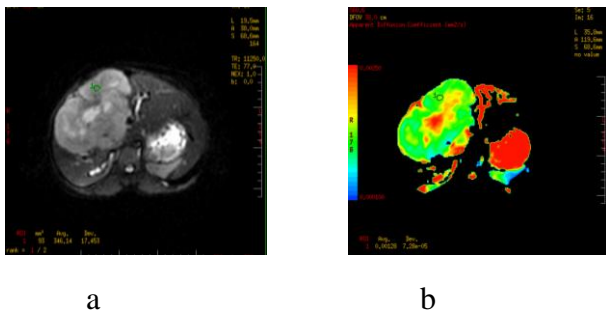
a) The axial DWI image showing HCC lesion with diffusion restriction, b) ADC of the same with ADC value as : $1.2 \times 10^{-3} \text{ mm}^2/\text{sec}$.
